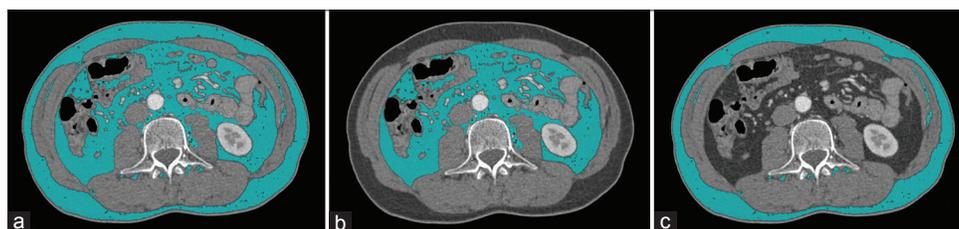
Axial computed tomography images showing the regions of interest of the total adipose tissue area (a), visceral adipose tissue area (b), and subcutaneous adipose tissue area (c)
